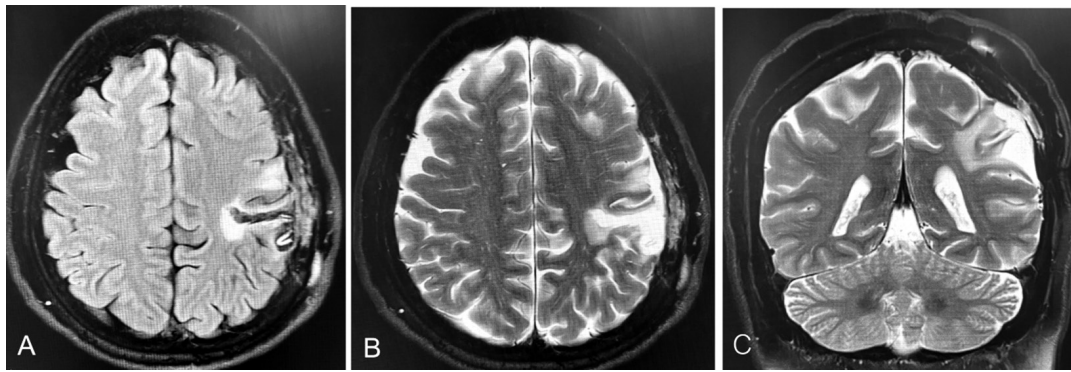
Axial T2-weighted image (A, B), coronal (C) demonstrated a small nodular dural lesion at posterior left parietal lobe. Encephalomalacia at left fronto-parietal lobe associated with evidence of old hemorrhage is noted.
